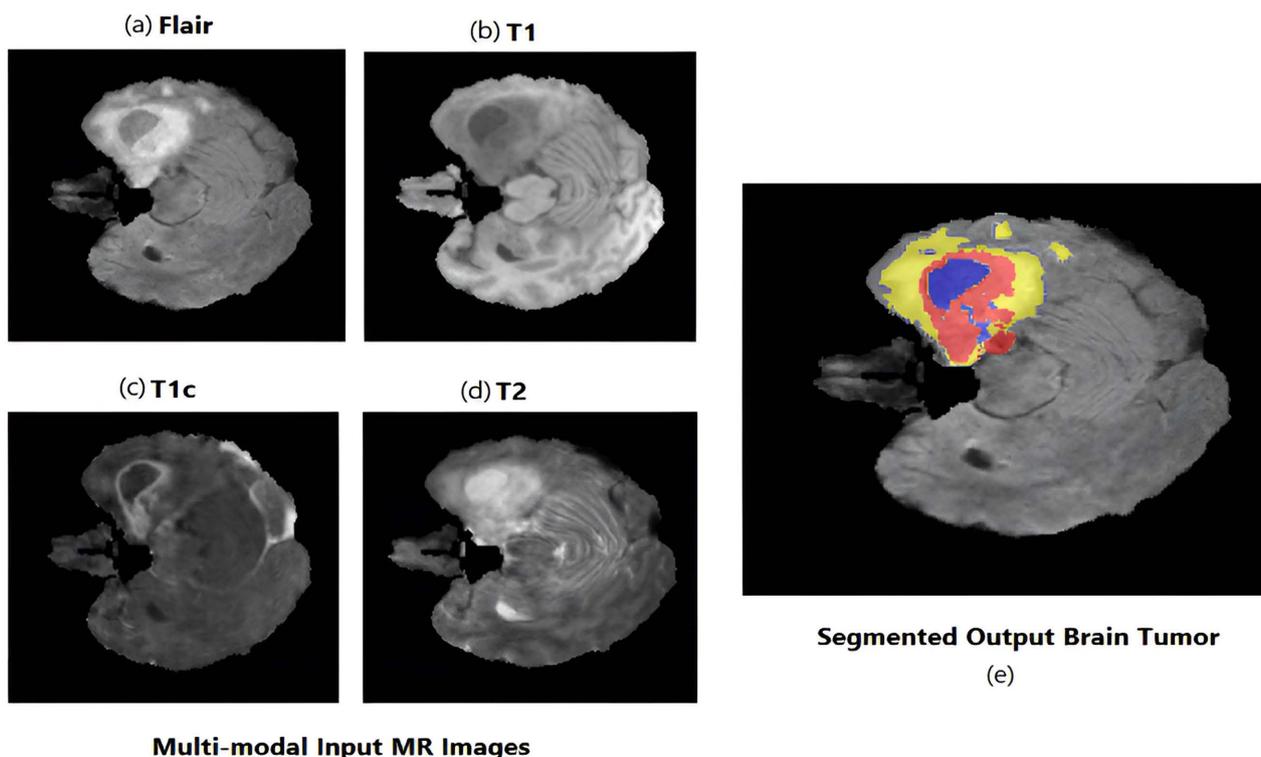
MRI modalities and corresponding tumour regions: (a) Flair image, (b) T1-weighted image without contrast, (c) T1c image with contrast enhancement, (d) T2 image, and (e) Final labels of combined tumor segmentations. Colour overlays denote tumour regions—yellow represents the whole tumour (Edema), brown indicates the enhancing tumour, and blue shows the tumour core (necrosis).
